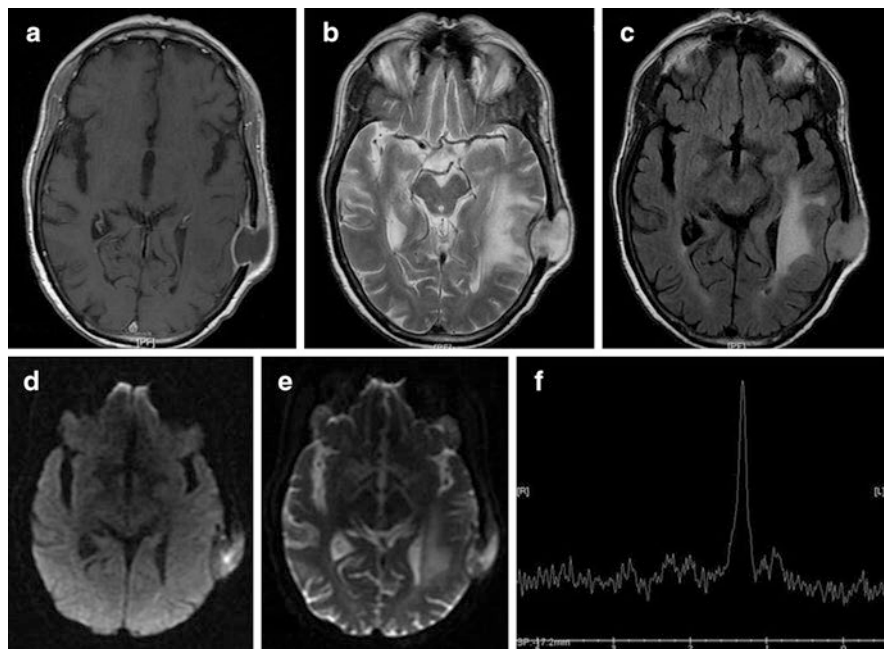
MRI picture of Chronic temporoparietal osteomyelitis
